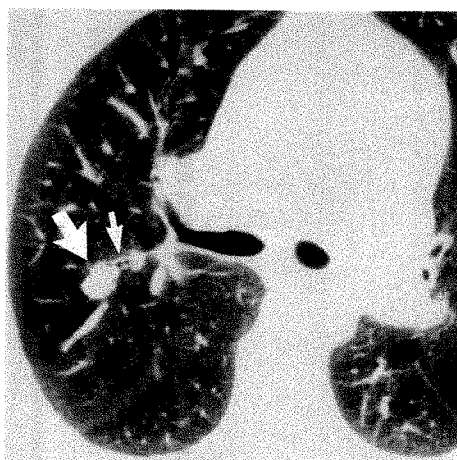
CT scan in patient with a small nodule in right lung shows nodule (large arrow) is closely related to posterior segmental bronchus of right upper lobe (small arrow). Because of this, it was approached bronchoscopically rather than with a percutaneous biopsy; brush cytology findings were positive.
